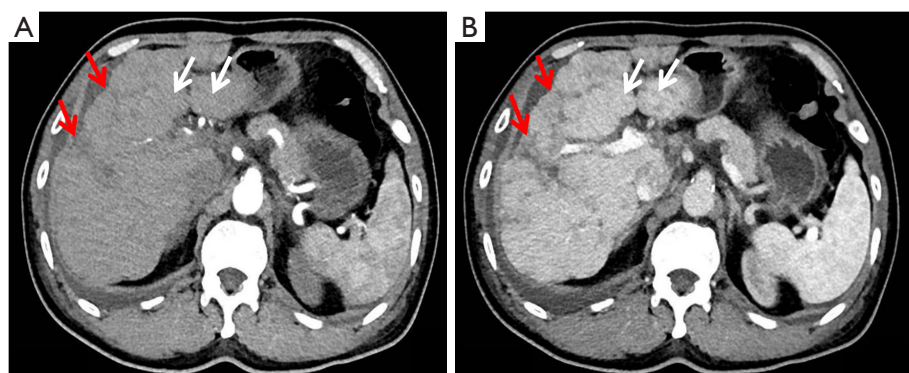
Computed tomography show a reduction in the size and number of metastases of Paget's disease in the liver. (A) Arterial phase, (B) venous phase: metastatic lesions (red arrows) and cirrhotic regenerative nodules (white arrows) in the liver were mixed and diffusely distributed throughout the liver shrank with treatment.
